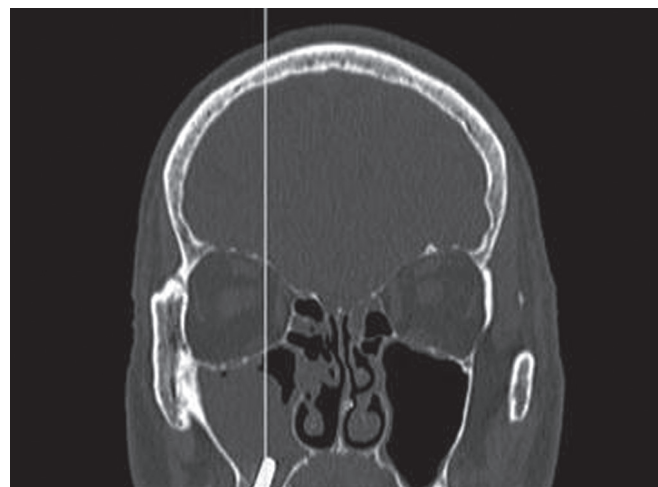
An infected dental implant protruding into the maxillary sinus causing maxillary sinusitis, as seen on a coronal computed tomography in the bone.
